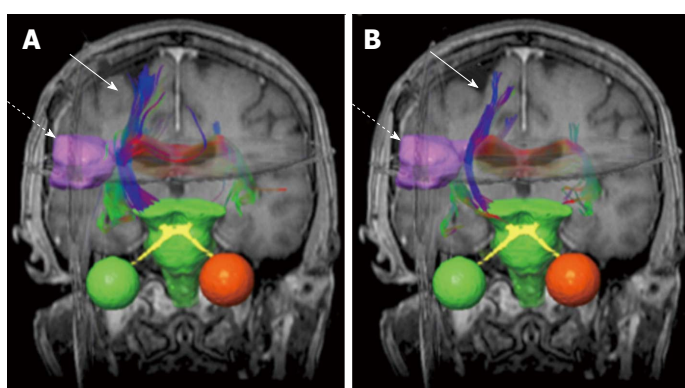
An example of brain neural fiber bundles (solid arrows) derived from diffusion tensor imaging data ($b = 500 \text{ mm}^2/\text{s}$). The pre-treatment (A) and post-treatment (B) results are superimposed on coronal T1-weighted magnetic resonance images. The dashed arrows indicate gross tumor volume (pink boundary).
